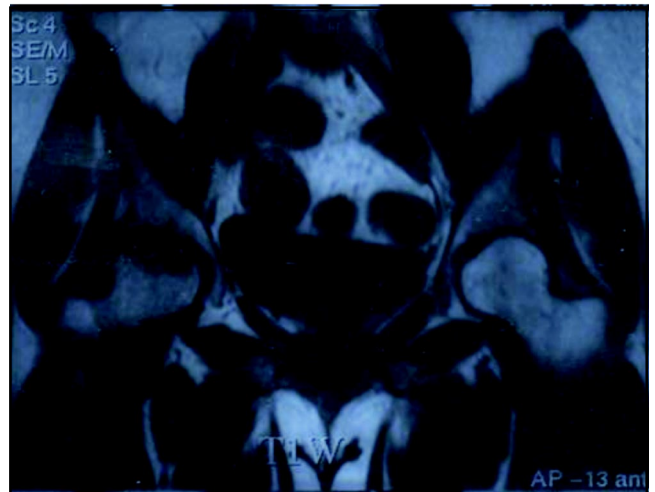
Repeat MRI 1 month later showed worsening of changes in right femur along with extension of hypo-intensity into the joint cavity.
